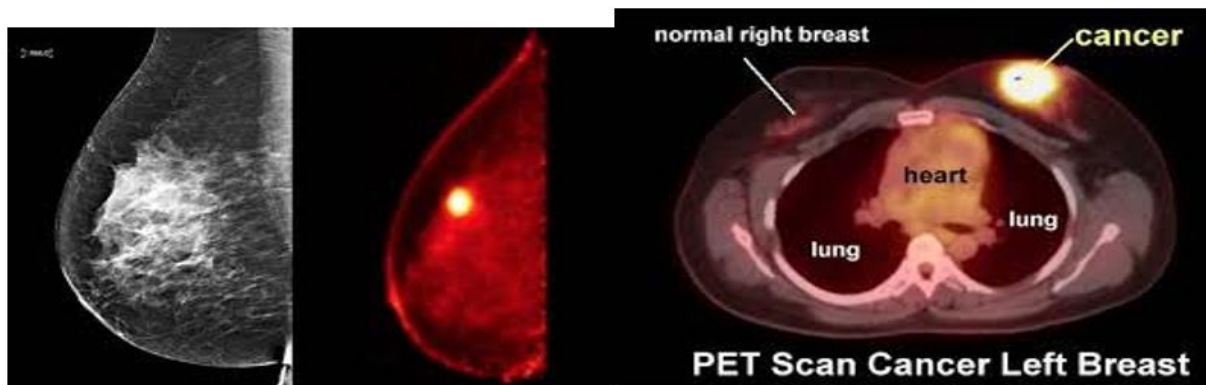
PET and PET CT scan of the breast
